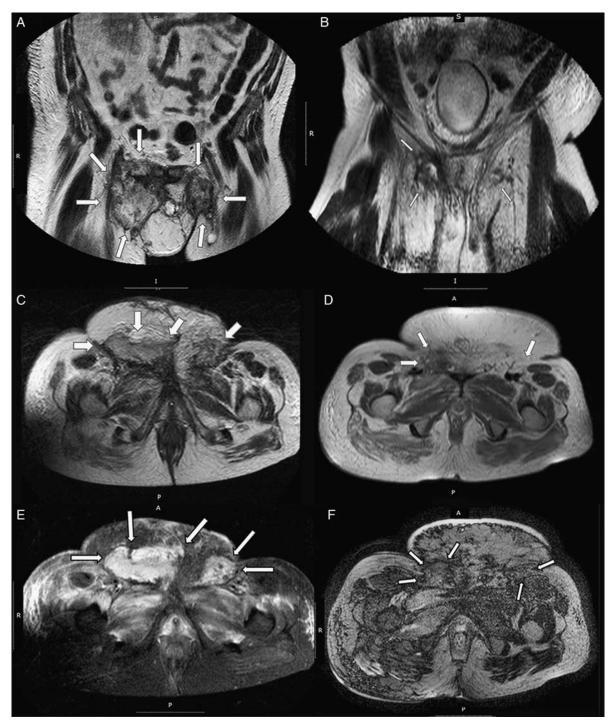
Magnetic resonance imaging (4/2016): T2w coronal (A), axial (C), and STIR axial (E) images; bilateral enlarged inguinal lymph nodes due to progression after cytotoxic chemotherapy and radiation therapy, before treatment with Nivolumab. Magnetic resonance imaging (9/2016): T2w coronal (B), axial (D), and STIR axial (F) images. High signal (possibly necrotic tissue) shrunk right inguinal lymph nodes due to response to immunotherapy with Nivolumab. Tumor lesions are indicated with white arrows.
